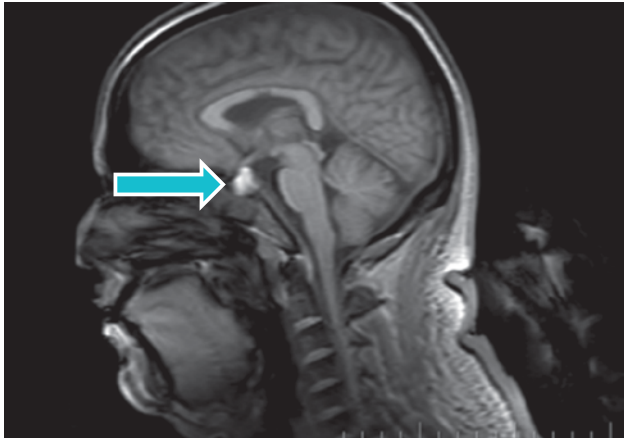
MRI of brain (T1-weighted)
